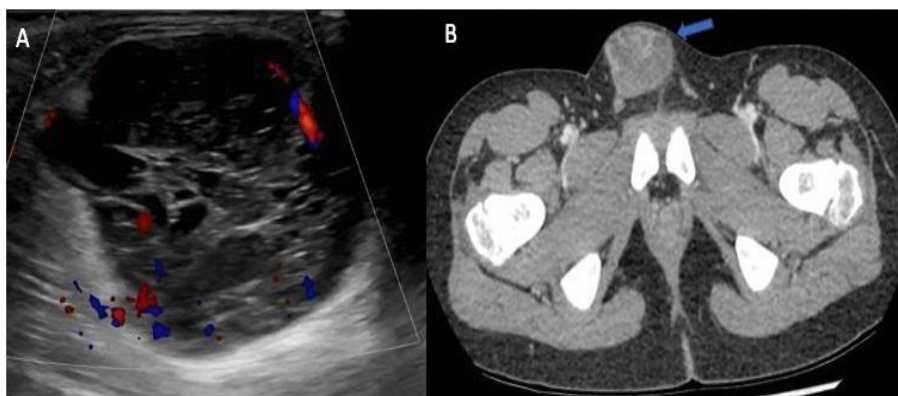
A) Ultrasound of the right inguinal region of a 12-year-old male showing heterogenous solid and cystic mass with some internal vascularity on Doppler sequences. B) Axial computed tomography scan of the pelvis showing a 3.9 x 3.7 x 4 cm heterogenous well circumscribed mass in the right inguinal region (arrow) anteriorly and separate from the spermatic cord.
